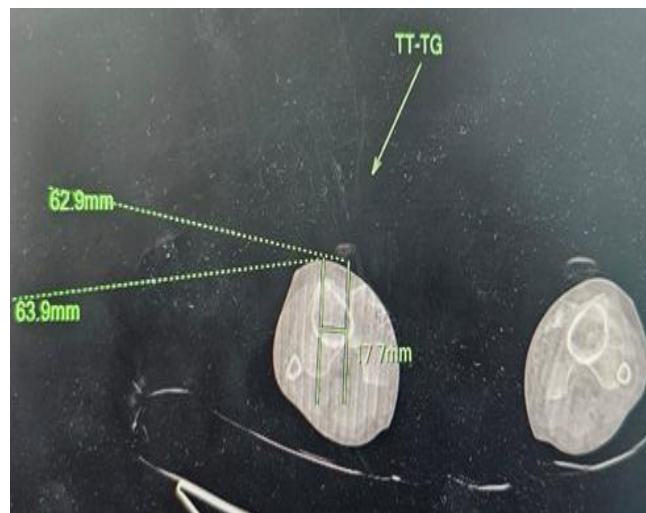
CT scan, axial view, measurement of femoral anteversion TT-TG distance.
